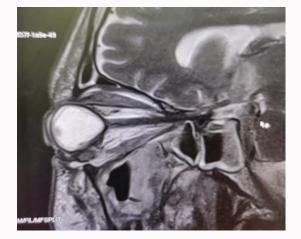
MRI reveals non-enhancing areas within thickened mucosa of left maxillary sinus suggestive of mucormycosis.
